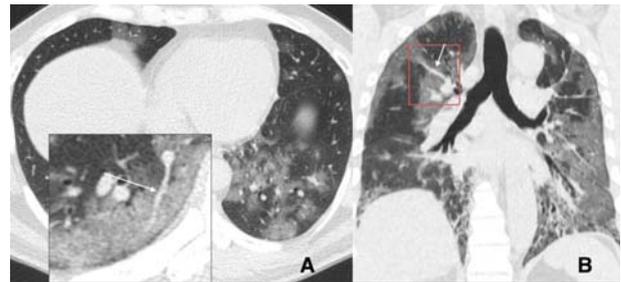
CT images of two different patients with COVID-19 with the 'prominent vessel sign' (white arrows in A and B) in the background of GGO.
